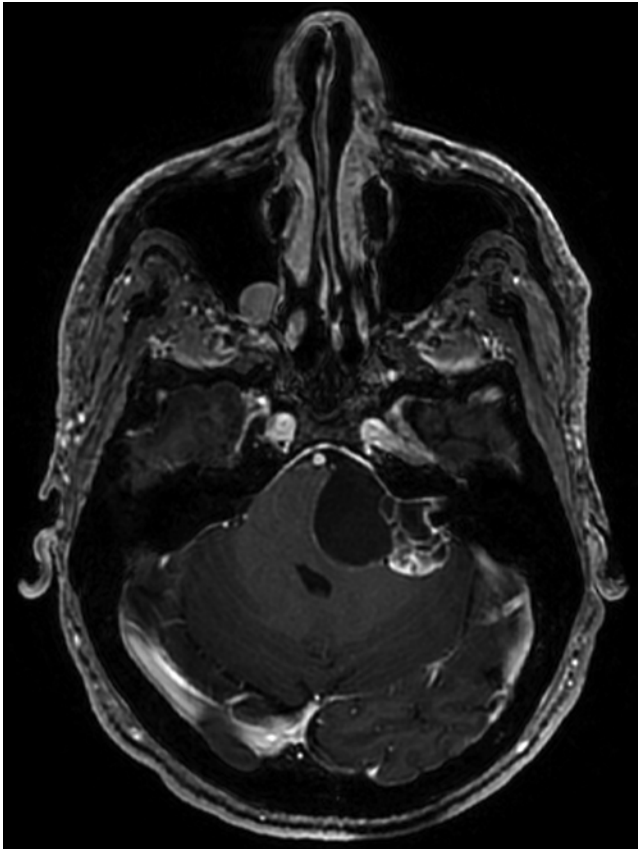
Preoperative axial contrast-enhanced T1-weighted MR image obtained at the level of the IAC and demonstrating a large left cystic vestibular schwannoma.
